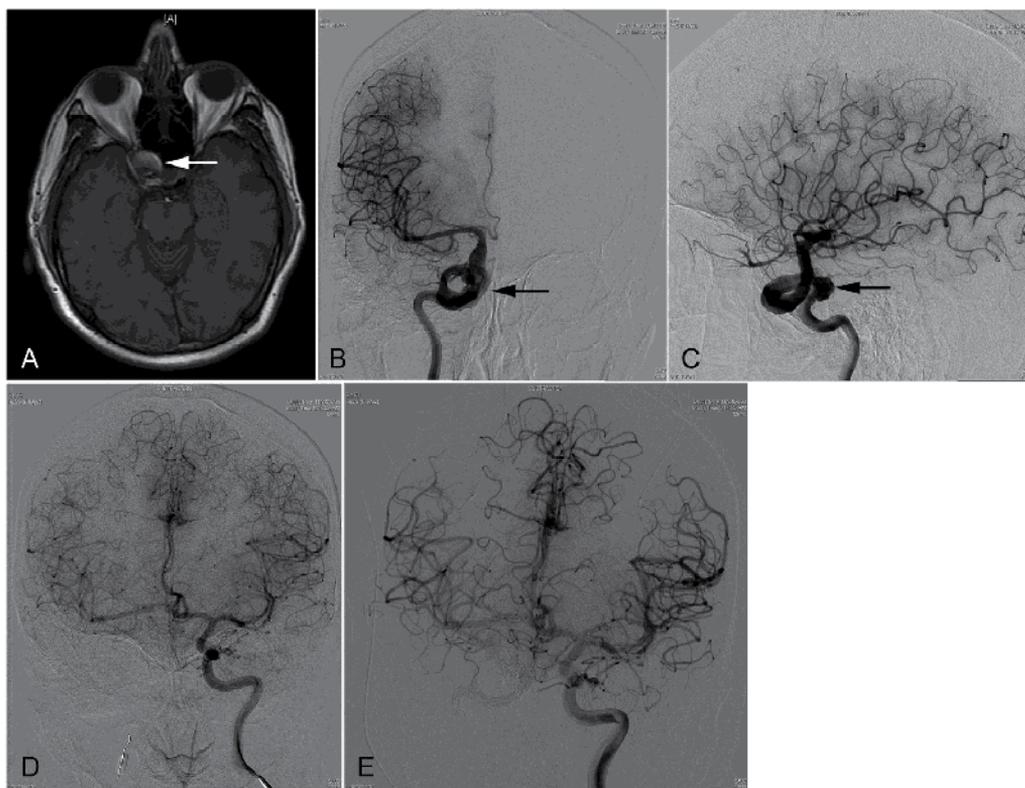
A 40-year-old man presented with amaurosis fugax in the right eye. An imaging study confirmed a partially thrombosed giant aneurysm of the right ICA cavernous segment that likely had caused the embolic event. (A) T1-weighted magnetic resonance image reveals a partially thrombosed cavernous aneurysm (*arrow*). (B and C) Angiography shows the fusiform aneurysm with serpentine channel (*arrow*). (D) Right ICA TBO test with angiogram from left ICA reveals robust cross-filling of the contralateral circulation. The ACoA serves to opacify the right ACA and MCA without delay. (E) The patient tolerated TBO and was successfully treated with right ICA sacrifice.
